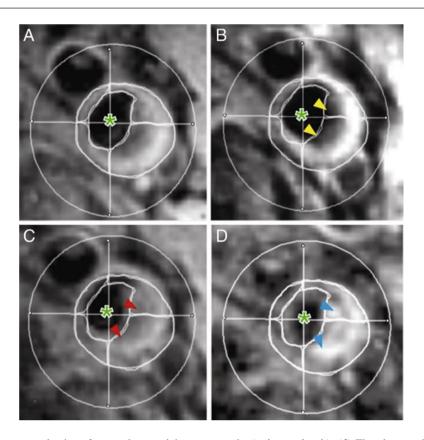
Atorvastatin therapy: evaluation of macrophage activity using ultrasmall superparamagnetic iron oxide-enhanced carotid MRI. T2*-weighted imaging of a right common carotid artery before and after ultrasmall superparamagnetic iron oxide (USPIO) infusion at the 2 time points of 0 (a and b) and 12 (c and d) weeks. (b) USPIO uptake can clearly be seen in the plaque at baseline (*yellow arrowheads*). (c) Sinerem has been cycled out of the plaque before reinfusion at 12
